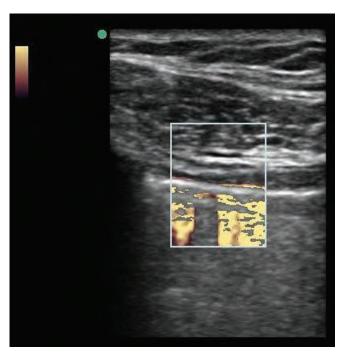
Power Doppler visualisation of normal lung
